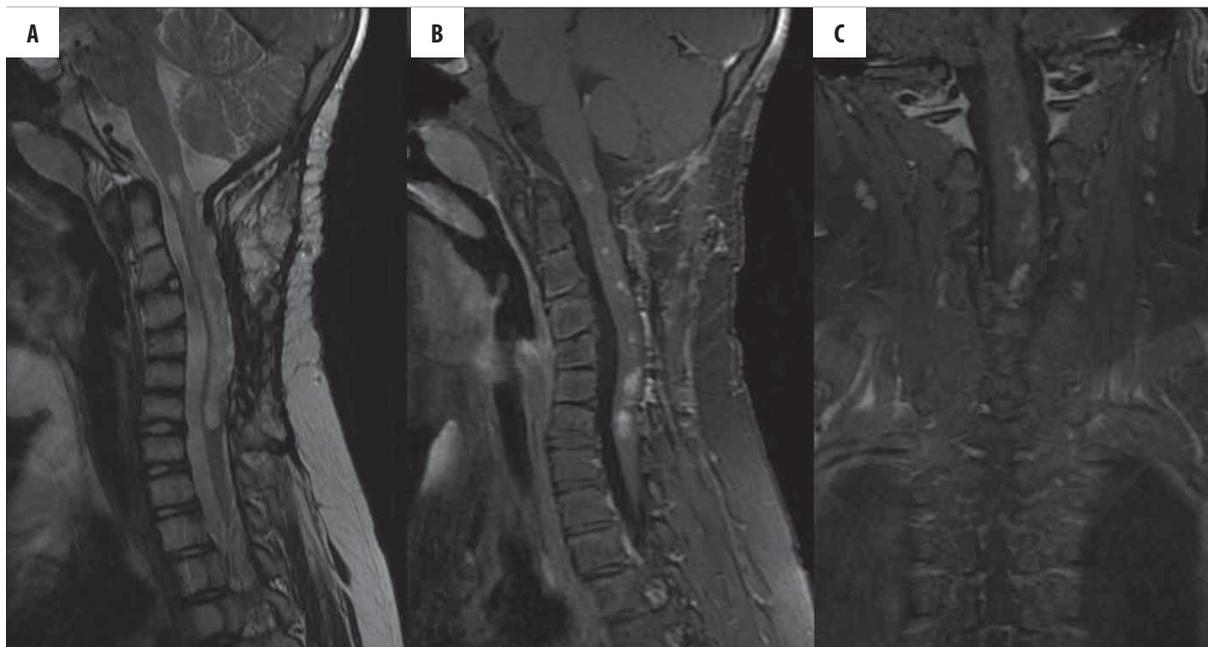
Large intramedullary tumor. MRI: sagittal T2-weighted fat-suppression (A), sagittal (B), and coronal (C) T1-weighted fat-suppression post-contrast images clearly visualize the extent of the tumor and contrast enhancement in the spinal cord.
